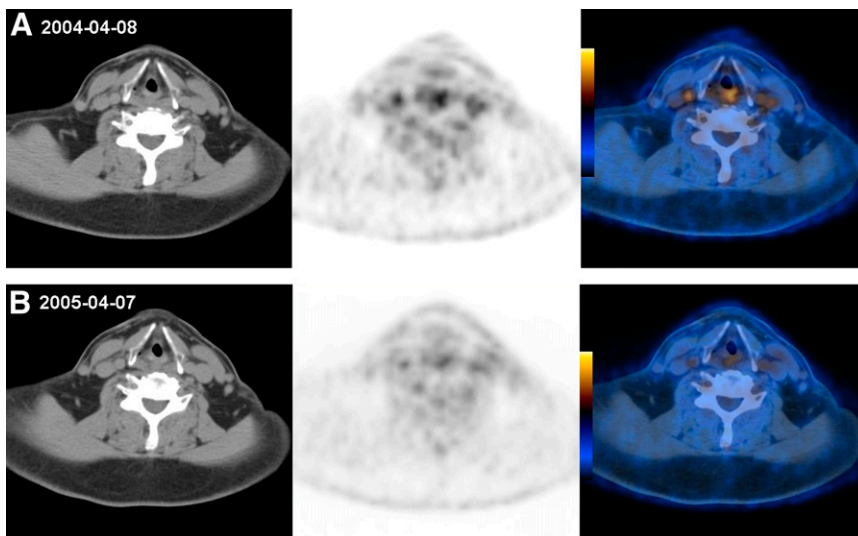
Serial ¹⁸F-FDG PET/CT images of 62-y-old male patient. (A) Initial study demonstrates focal site of increased ¹⁸F-FDG uptake in right common carotid artery. Lesion-to-blood-pool peak SUV ratio was 1.2. (B) On 1-y follow-up study, carotid artery lesion was no longer visible, and peak SUV ratio was reduced to 0.9.
